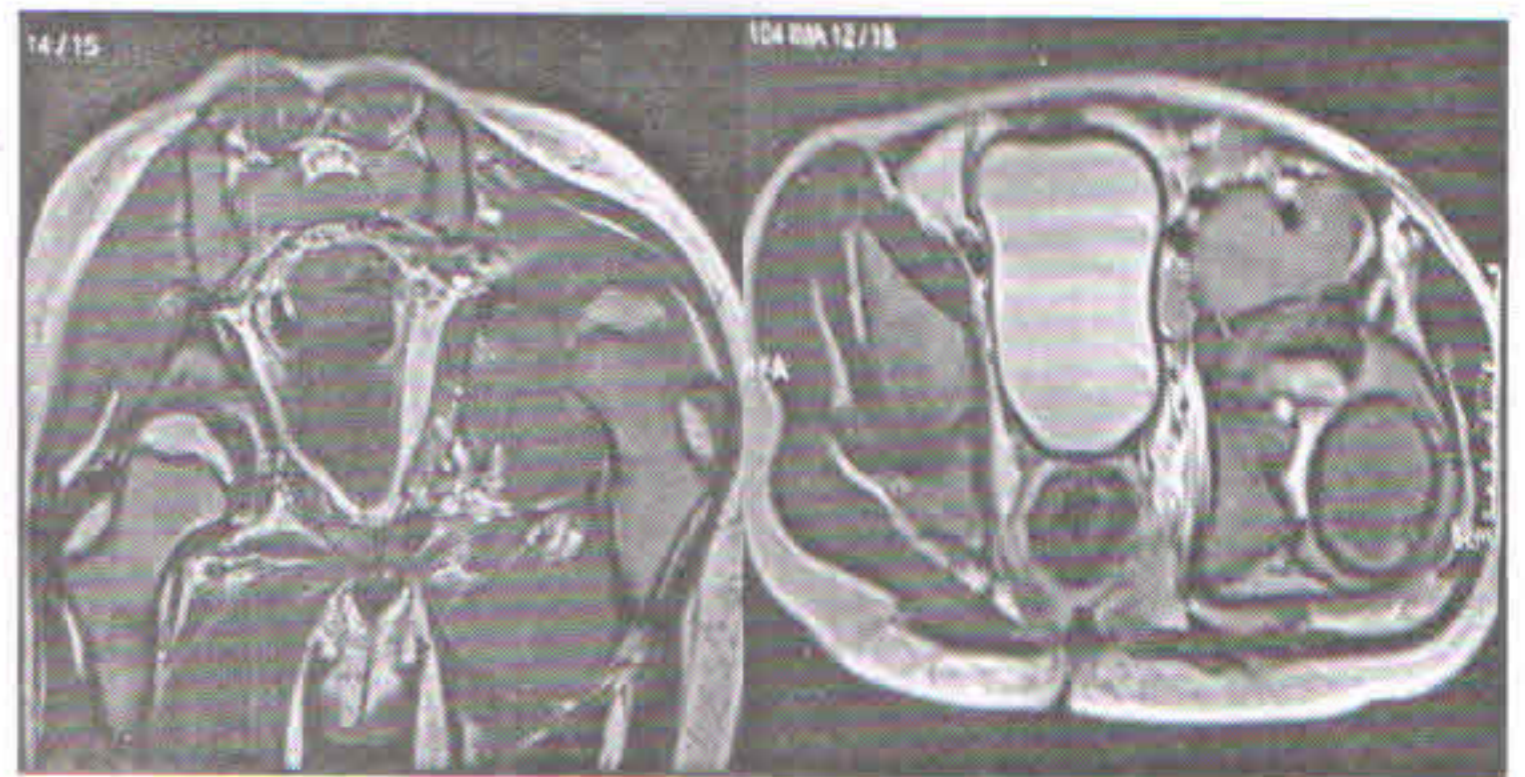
MRI showing tubercular destruction and pathological dislocation of left hip
